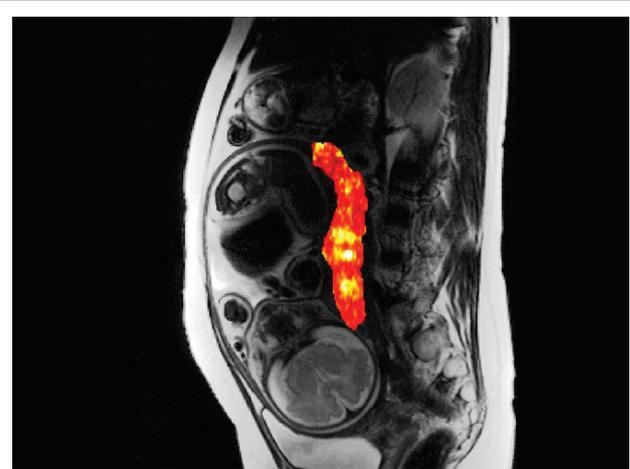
High resonant ultrasound of multiple pregnancy complication.
